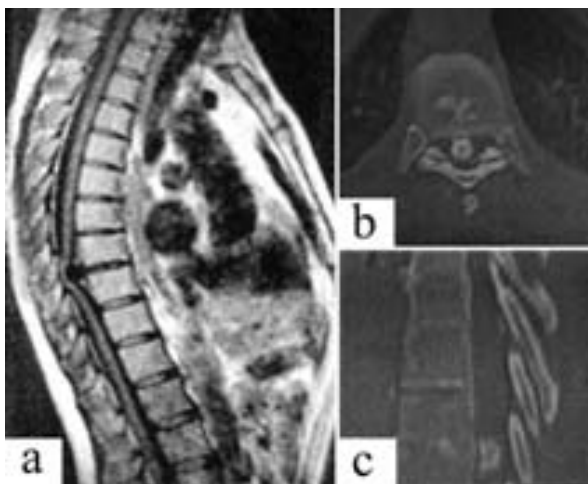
MRI and CT of the thoracic spine.
